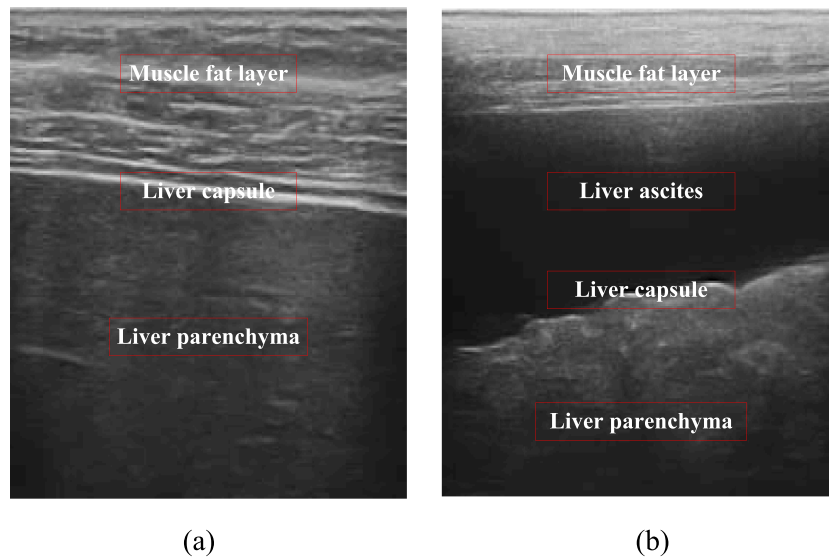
Introduction of ultrasound image structure
